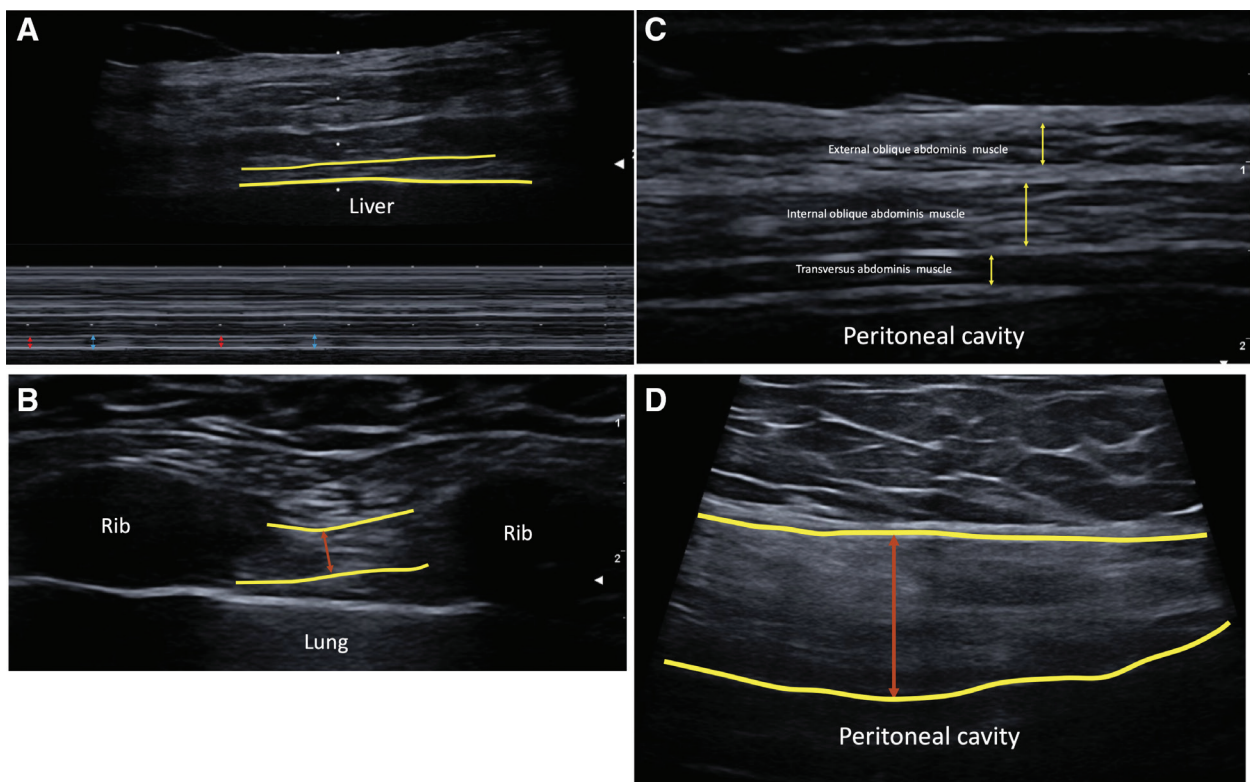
Respiratory muscles ultrasound. The ultrasound of respiratory muscles is depicted. (A) Diaphragmatic ultrasound for thickness during inspiration (red arrows) and expiration (blue arrows) in M-mode. (B) Intercostal muscles ultrasound. (C) Abdominal wall muscles ultrasound for thickness of external and internal oblique abdominis muscles and transversus abdominis muscle. (D) Rectus abdominis ultrasound for thickness. External and internal boundaries of the muscles are traced in yellow. The orange arrows refer to thickness of the muscles.
